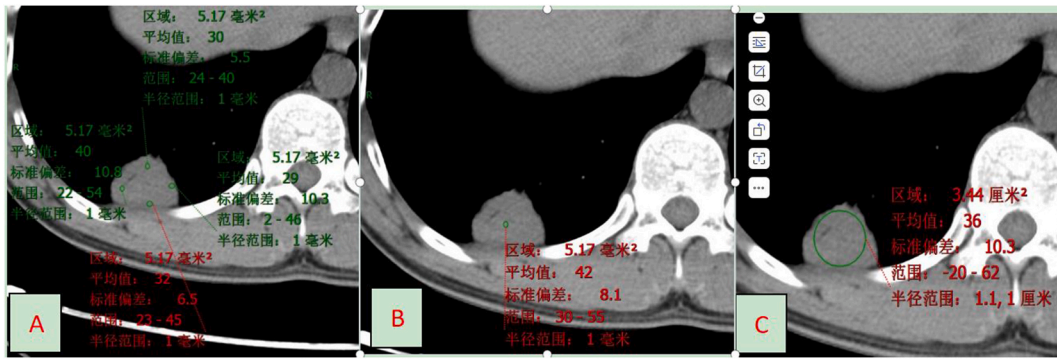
the method of measuring CT value,the peripheral CT values were selected as the average of the measured values of the upper, lower, left and right ends of the lesions(A), the central and peripheral CT values were measured over an area of 4.80mm²-5.20mm²(B). The global CT values of irregular lesions were measured over a larger solid area if possible(C).
